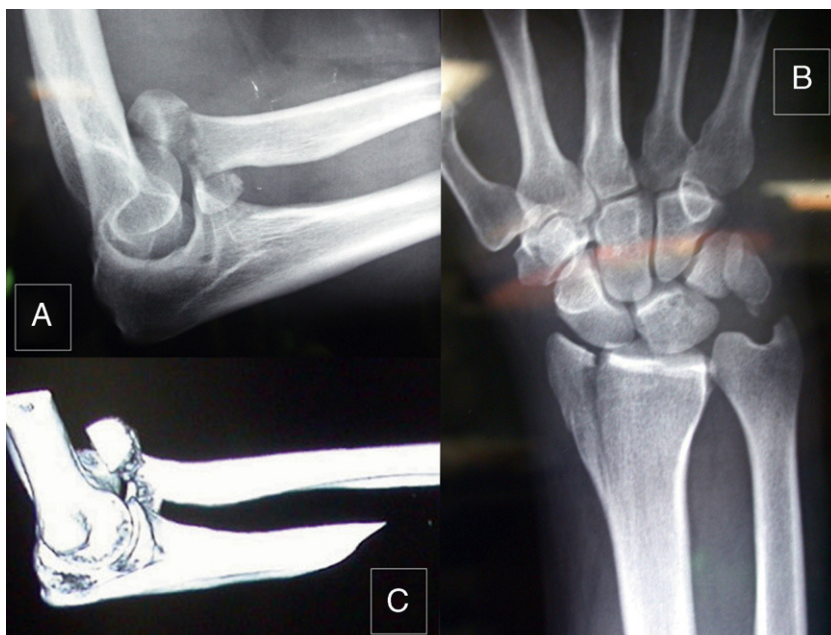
Right elbow: (A) X-ray of elbow profile; (B) AP X-ray of the wrist; (C) computed tomography (CT) scan.
